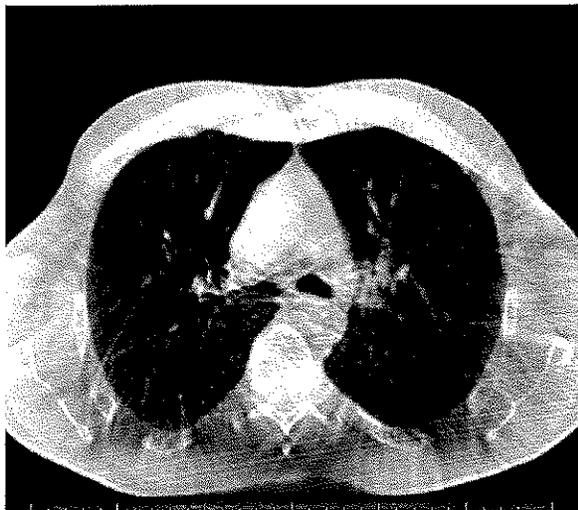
Movement artefacts on an axial slice from a CBCT acquired during normal breathing. (Courtesy of Varian Medical Systems and Hirslanden Klinik, Aarau).
